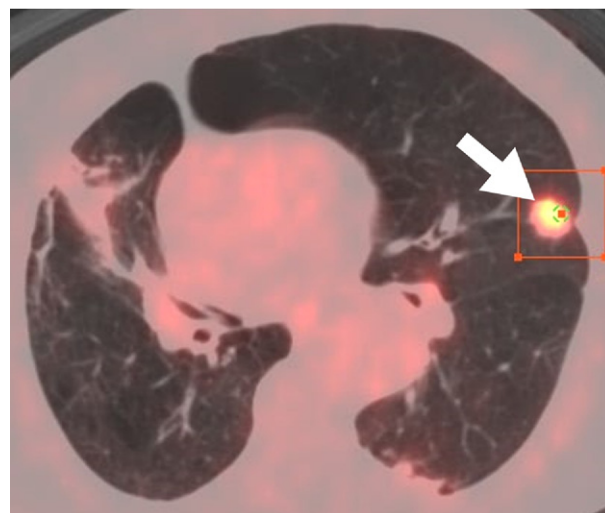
Axial PET/CT image of biopsy-proven squamous cell carcinoma in a 79-year old man. The image shows increased uptake (standardized uptake value of 9.3) within the nodule (arrow).
